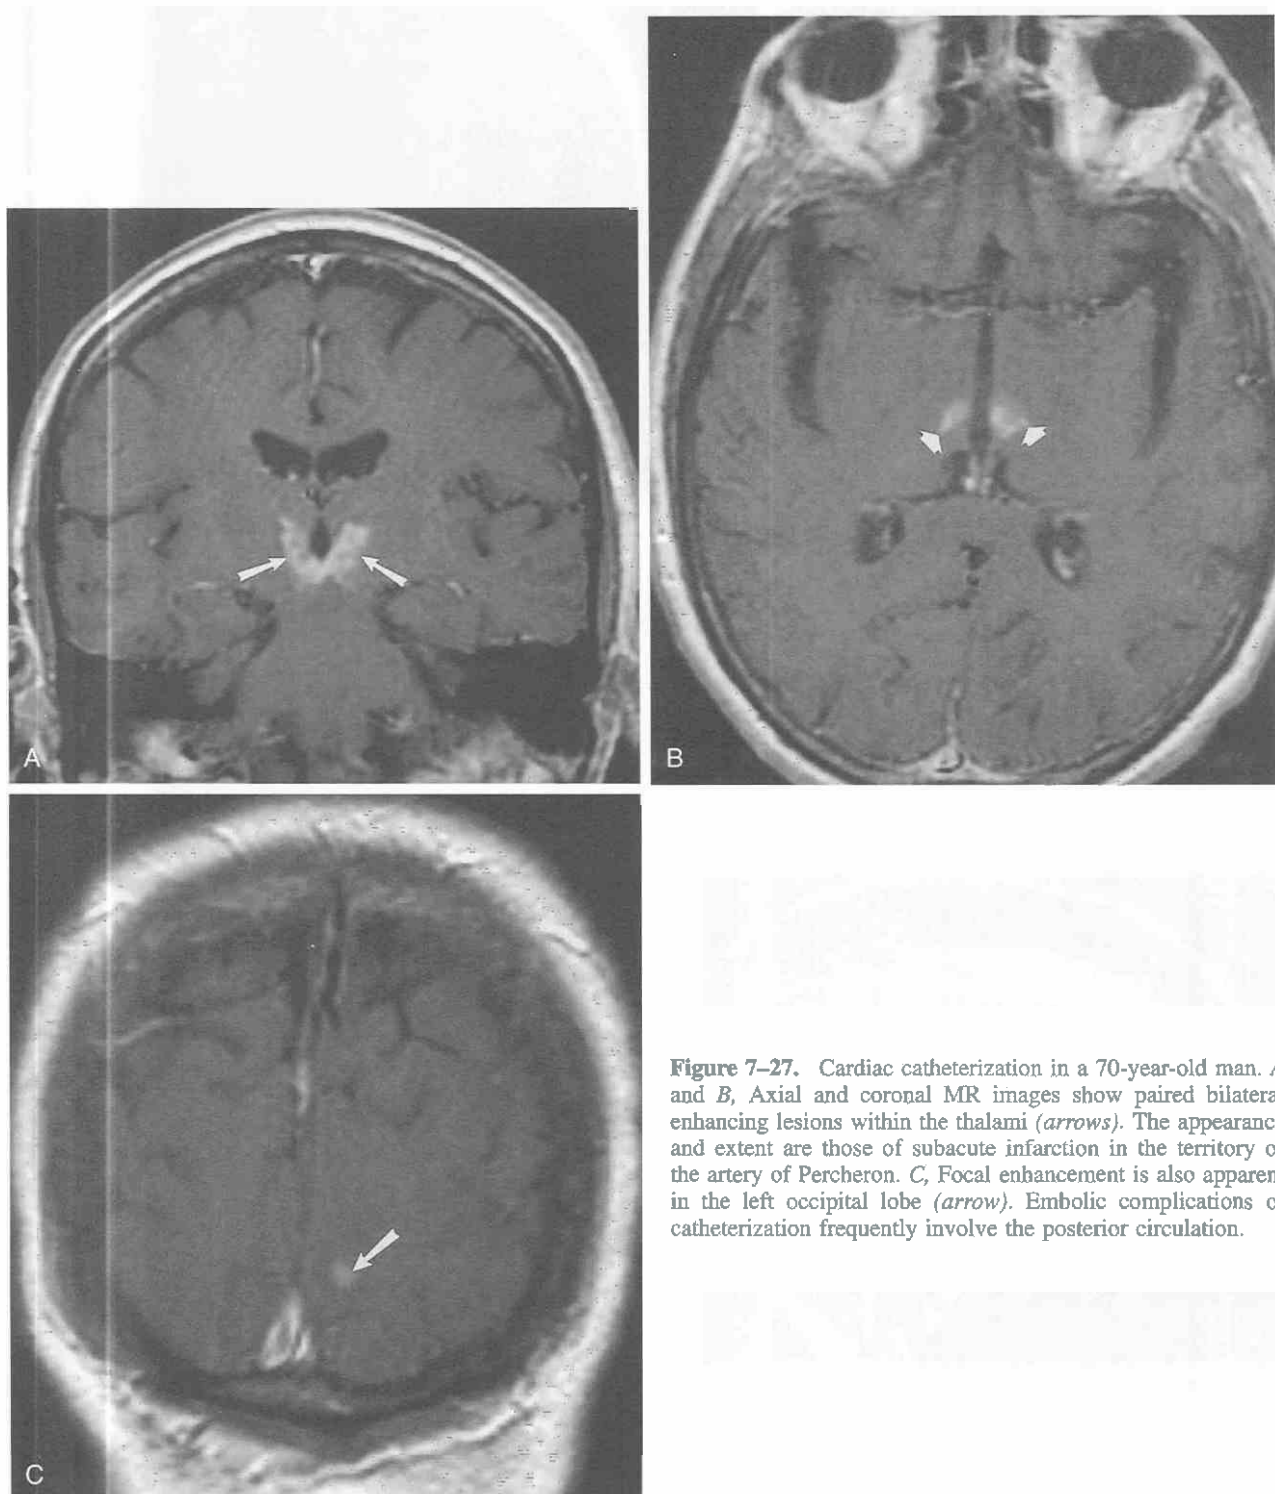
Cardiac catheterization in a 70-year-old man. *A* and *B*, Axial and coronal MR images show paired bilateral enhancing lesions within the thalami (*arrows*). The appearance and extent are those of subacute infarction in the territory of the artery of Percheron. *C*, Focal enhancement is also apparent in the left occipital lobe (*arrow*). Embolic complications of catheterization frequently involve the posterior circulation.
